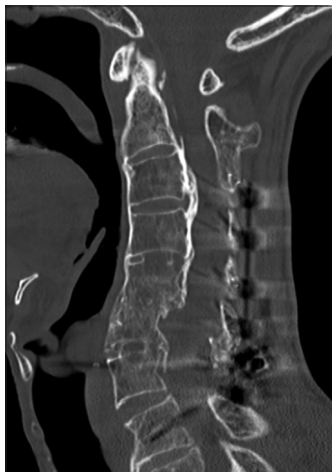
Computed tomography image 6 months postoperatively: Midline sagittal image
